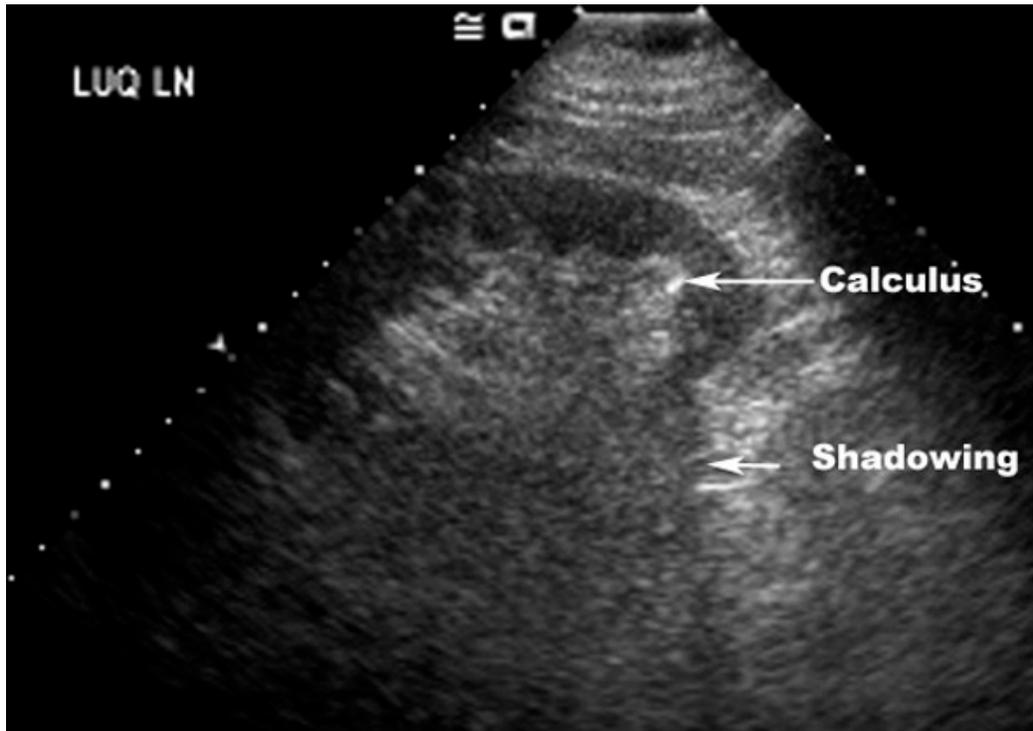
Renal calculus on a real ultrasound*
